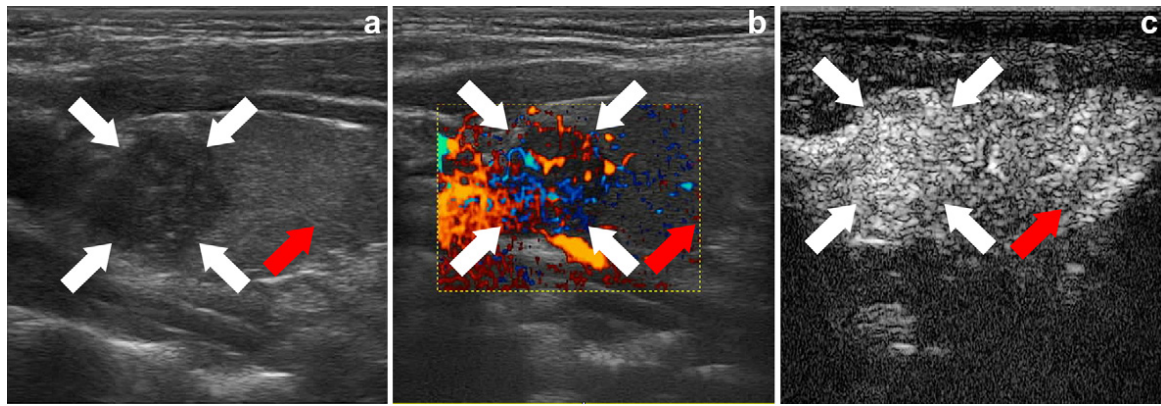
(a) High-resolution ultrasonography (HRUS) image of a papillary carcinoma. The white arrow indicates the nodule; the red arrow indicates the healthy thyroid parenchyma. (b) Color Doppler image of the papillary carcinoma showing marked vascularization of the lesion (white arrows) compared with healthy parenchyma (red arrow). (c) Contrast-enhanced ultrasound imaging (CEUS) image of the papillary carcinoma showing marked enhancement of the lesion (white arrows) compared with healthy parenchyma (red arrow). All three images are same projection and slice.
